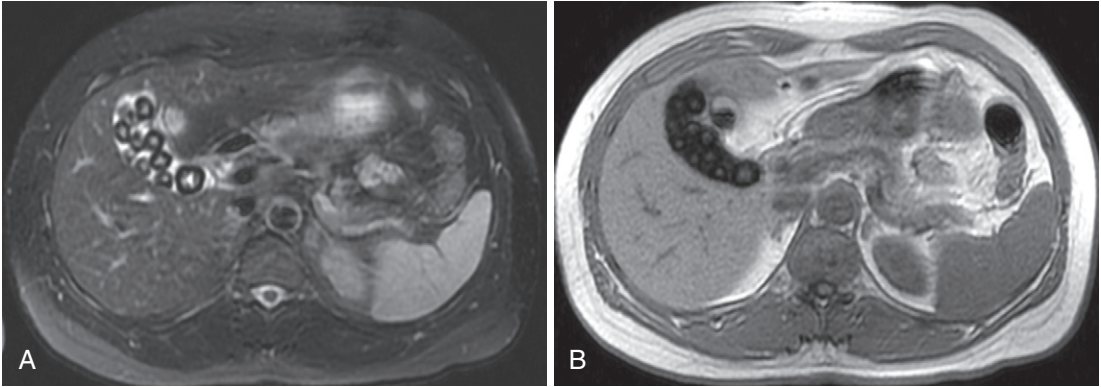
Cholelithiasis. The axial T2-weighted fat-suppressed image (A) through the gallbladder shows multiple intraluminal filling defects corresponding to gallstones. In the in-phase image (B), the gallstones are conspicuous only because of the hyperintensity, suggesting pigmented composition.
